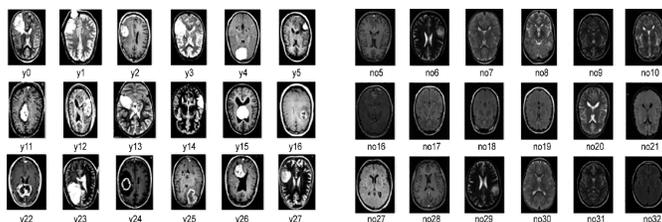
MRI images of two categories: a) with tumor b) without tumor
